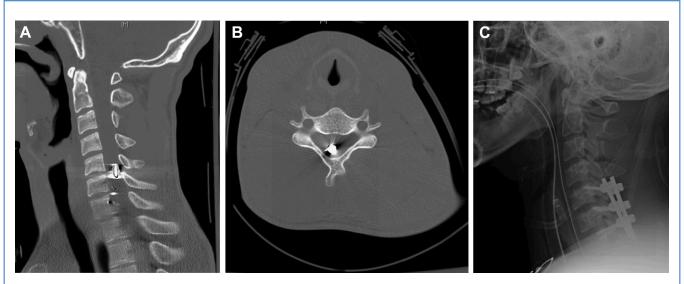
(A) Sagittal CT scan showing bullet within the spinal canal between C5 & C6. (B) Axial CT cuts showing same bullet at the C5 level. (C) Post
